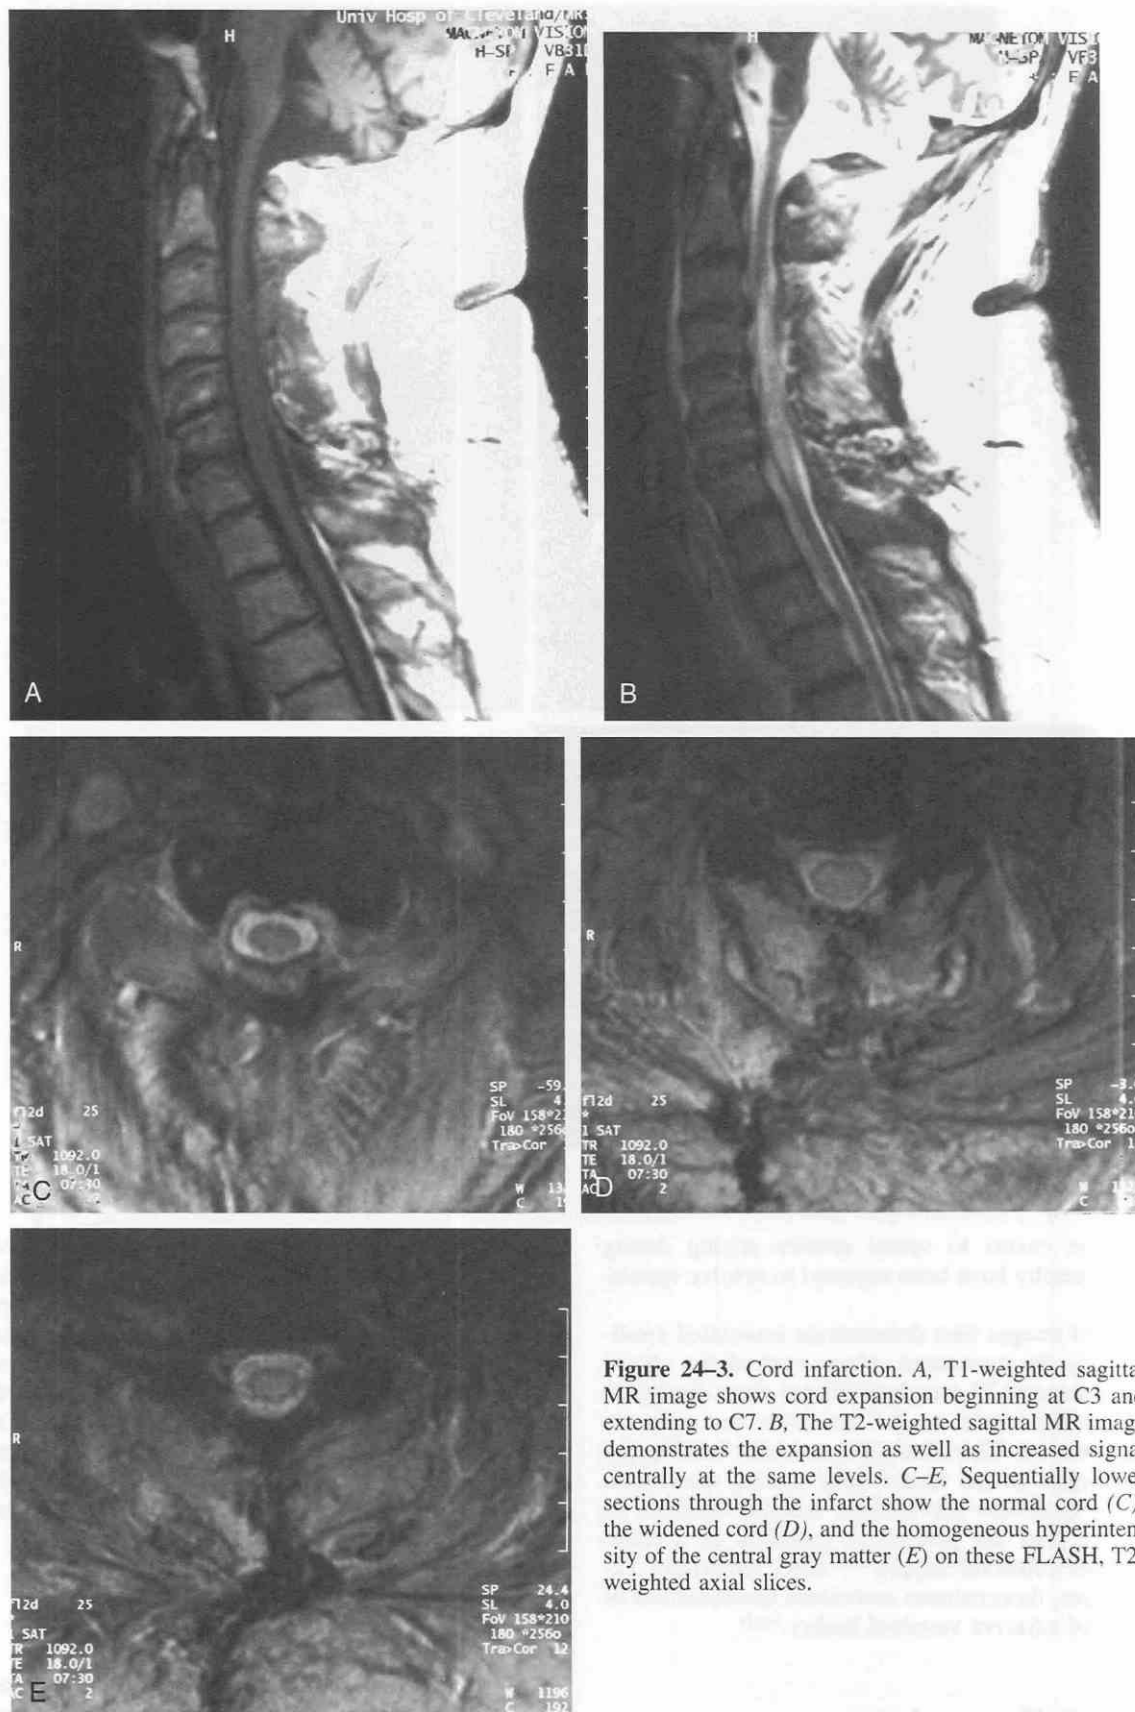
Cord infarction. A, T1-weighted sagittal MR image shows cord expansion beginning at C3 and extending to C7. B, The T2-weighted sagittal MR image demonstrates the expansion as well as increased signal centrally at the same levels. C–E, Sequentially lower sections through the infarct show the normal cord (C); the widened cord (D), and the homogeneous hyperintensity of the central gray matter (E) on these FLASH, T2-weighted axial slices.
